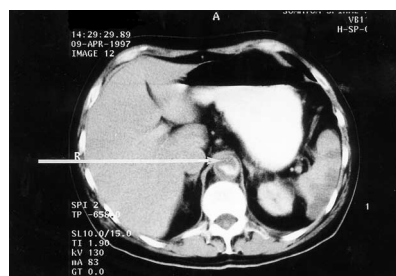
Computed tomography scan of the abdomen with contrast, showing severe narrowing of the aorta as a result of an aortic angiosarcoma (arrow).
